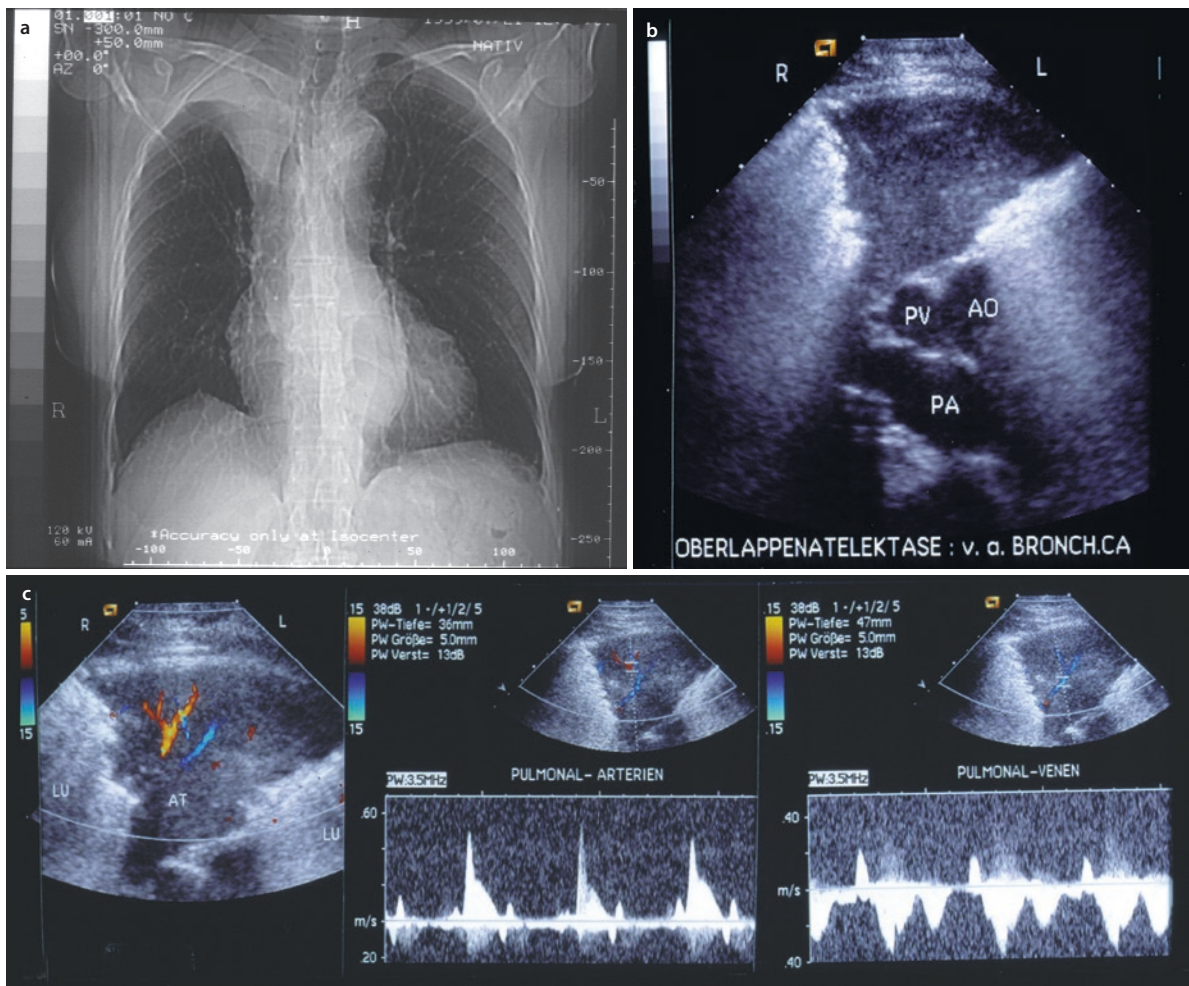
A 74-year-old woman with dyspnea. a Chest X-ray: signs of right-sided upper-lobe atelectasis. b Sonography: right-ventral intercostal echo transmission shows a smoothly margined, wedge-shaped hypoechoic transformation of the lung as in atelectasis. The central vessels are seen; a shadow of the tumor core cannot be
